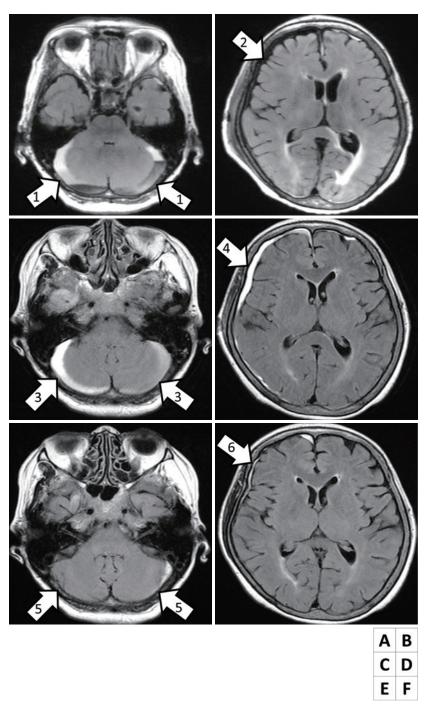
Magnetic resonance image of the present case.
